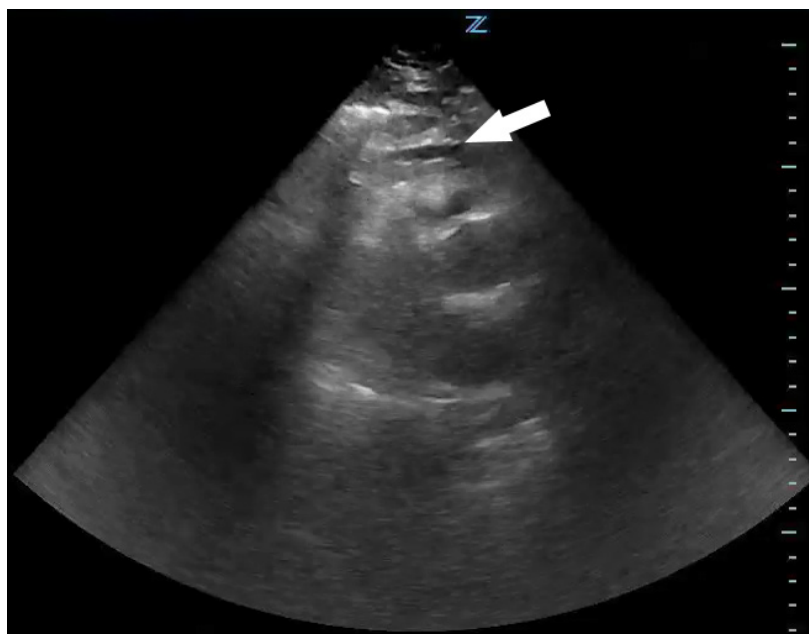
Point-of-care cardiac ultrasound, parasternal long axis view, showing a small pericardial effusion (arrow). See the supplemental file "Video1.mp4" for a video of this ultrasound.
